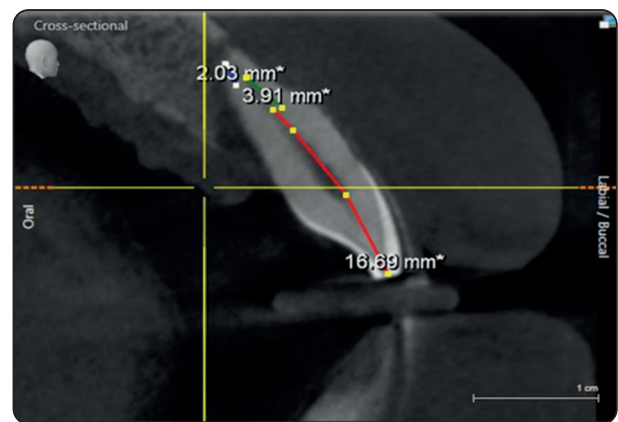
Showing working length determination on the preoperative cbct radiograph on the upper left lateral incisor
